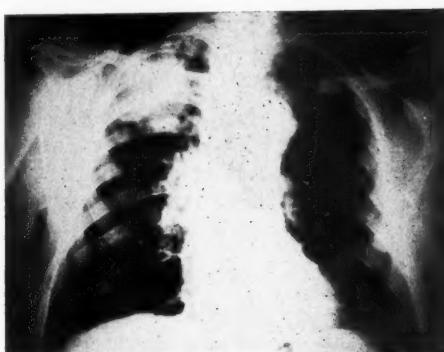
Case 9. X-ray (postero-anterior) showed opacity in the right upper lobe (silent primary).
